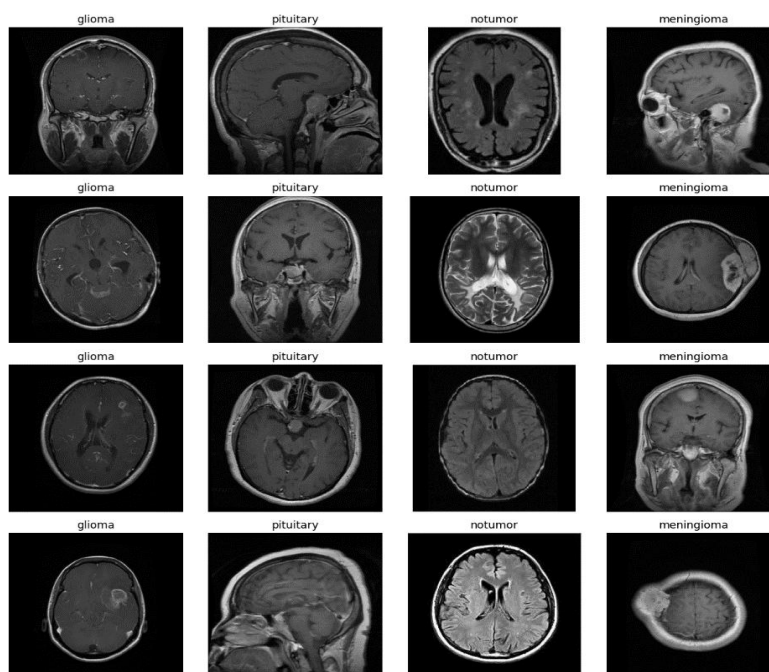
Sample images of training brain tumor MRI dataset
